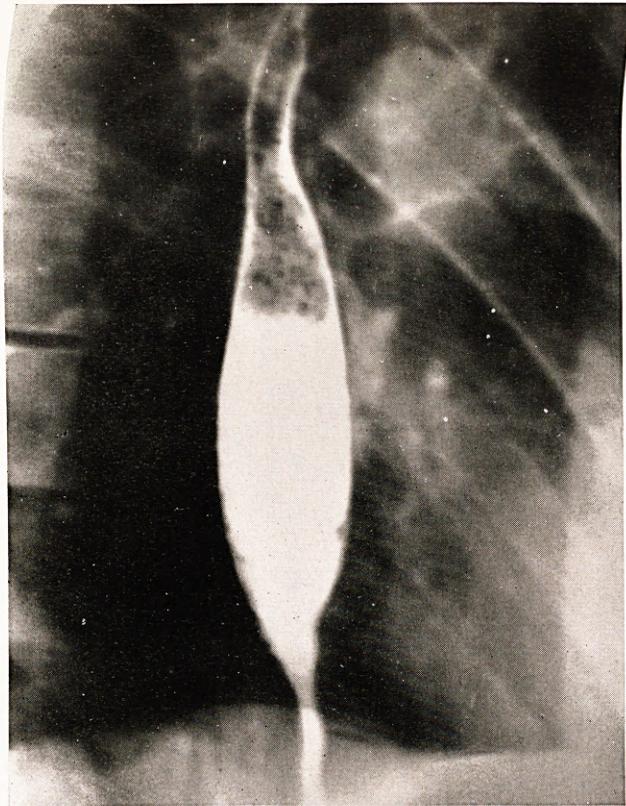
X-ray of barium swallow three weeks after vagotomy, in a patient complaining of mild dysphagia.
